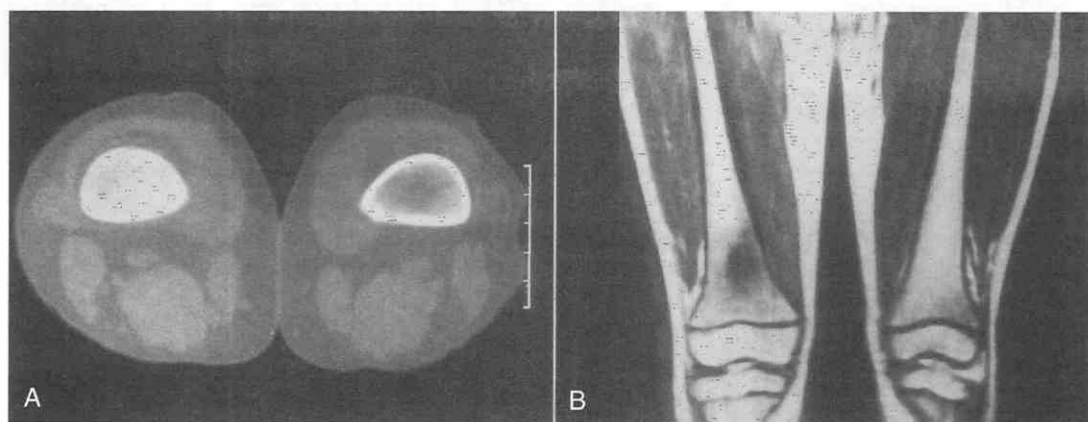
Intramedullary osteoid osteoma in a 9-year-old girl with knee pain. A, CT scan reveals an area (nidus) of sclerosis with a central lucency in the medullary cavity. B, Coronal T1-weighted spin-echo image (TR = 650 msec, TE = 20 msec) demonstrates an area of decreased signal intensity corresponding to the sclerosis seen in A; the nidus shows intermediate signal intensity.
